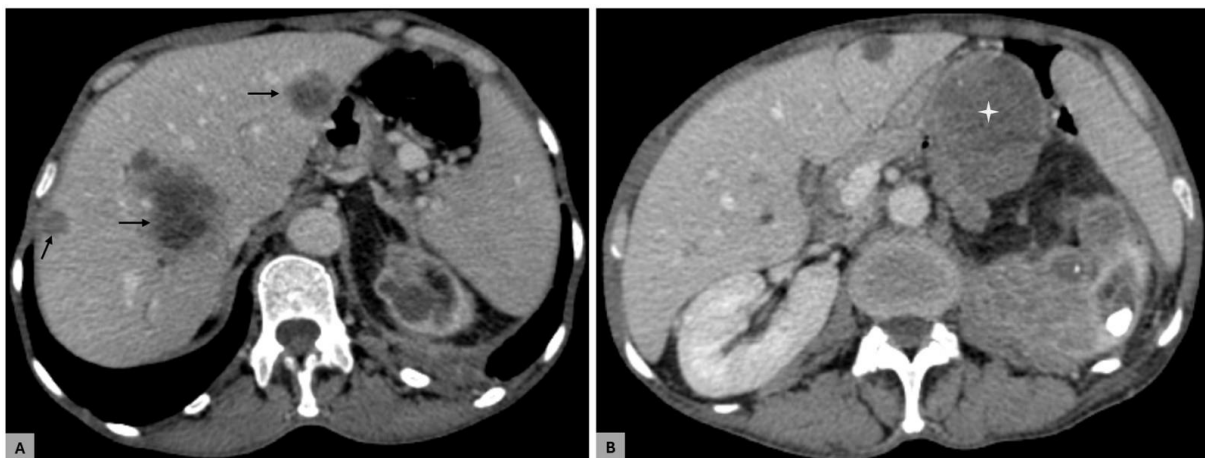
Axial contrast-enhanced computed tomography images demonstrating multiple hypodense lesions within liver consistent with metastatic deposits (black arrows), associated with enlarged lymph nodes suggestive of metastatic lymphadenopathy (white asterix).
